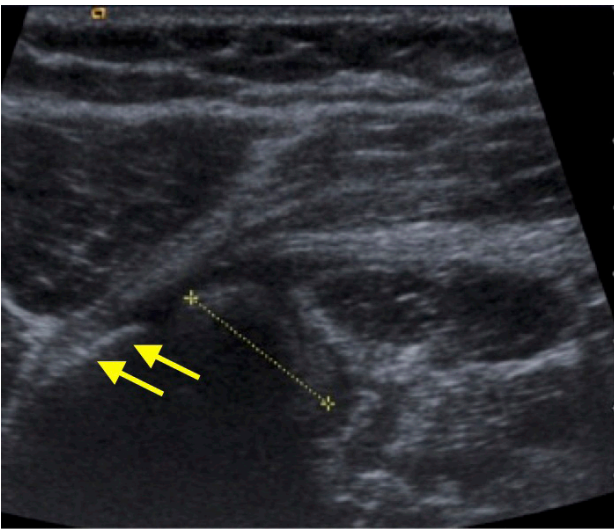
Transverse sonographic image of the upper arm demonstrating the calcific loose body (calipers) within the inferior biceps tendon sheath. Note the humeral cortex (arrows).
